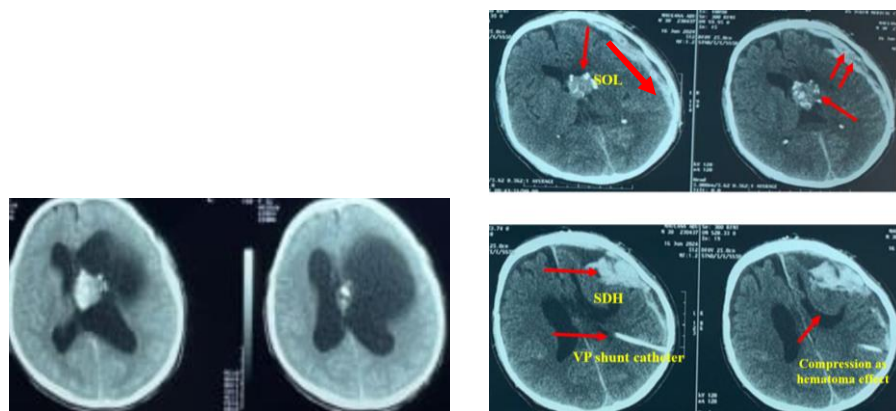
Head CT scan. A. Before VP shunt. B. After VP shunt: showed mass tumor and more recovery from hydrocephalus. C: Subdural hemorrhage (SDH).
